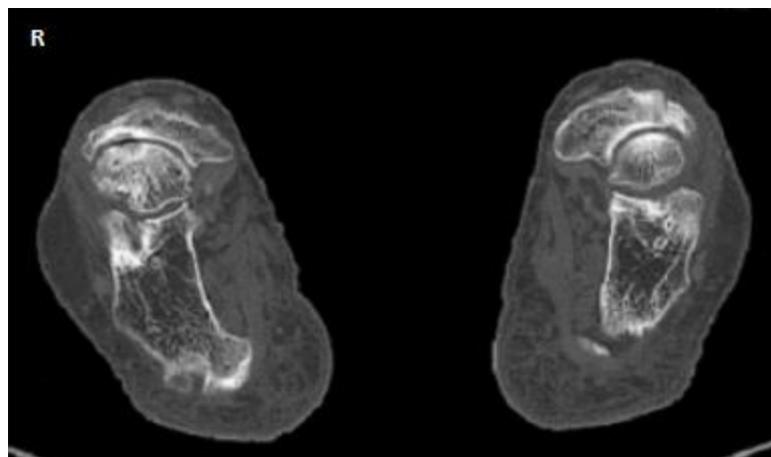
Axial CT Scan of both feet showing a collapse of the lateral part of the navicular bones, with significant condensation.
